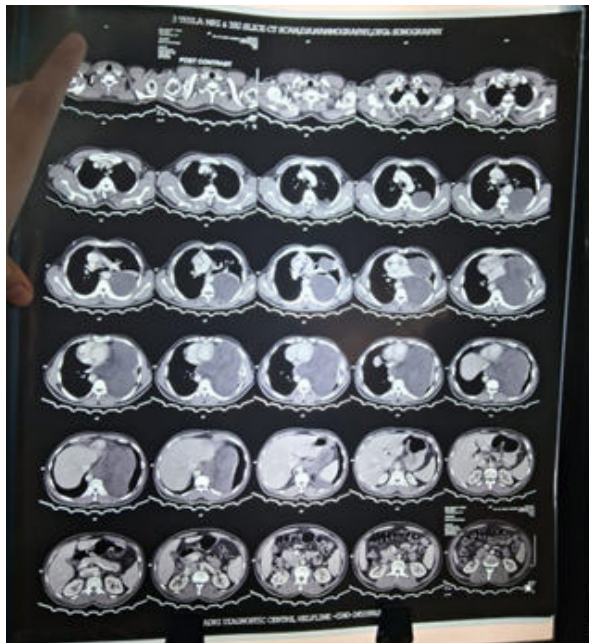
CT s/o a large solid mass lesion in left hemithorax
